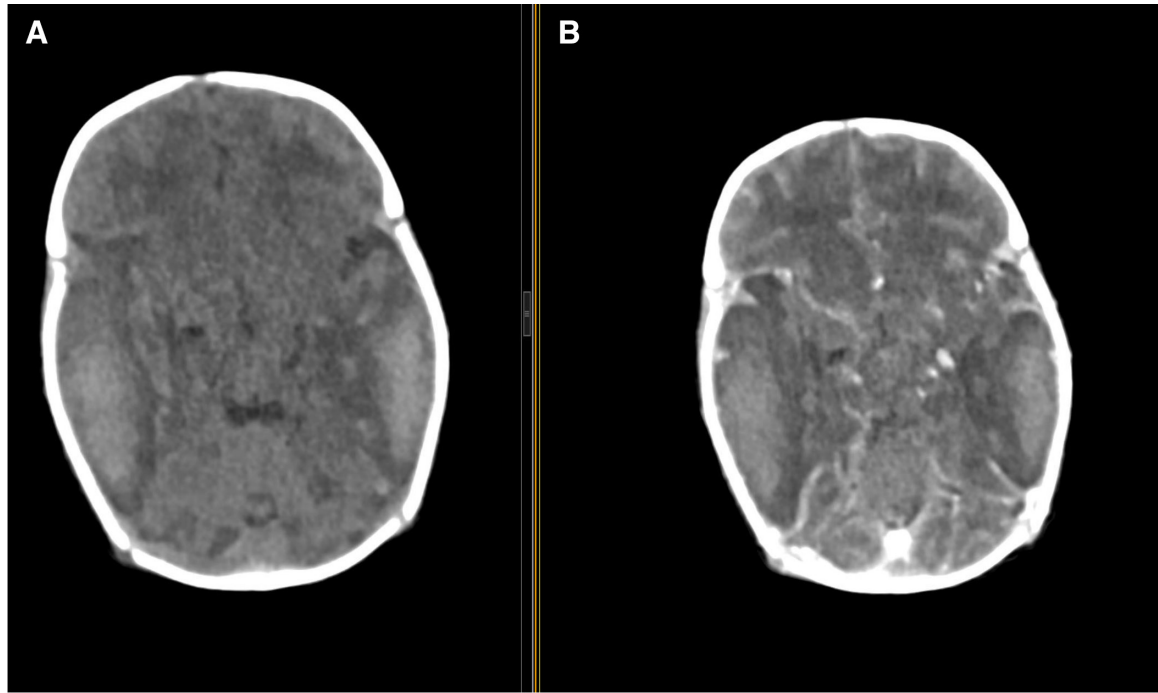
Axial non-enhanced contrast CT (A) and axial contrast E-enhanced CT (B) show multiple non- enhancing hyper dense (49.7 HU) areas with perilesional oedema in the right frontal –temporal and left temporal parietal lobes.
